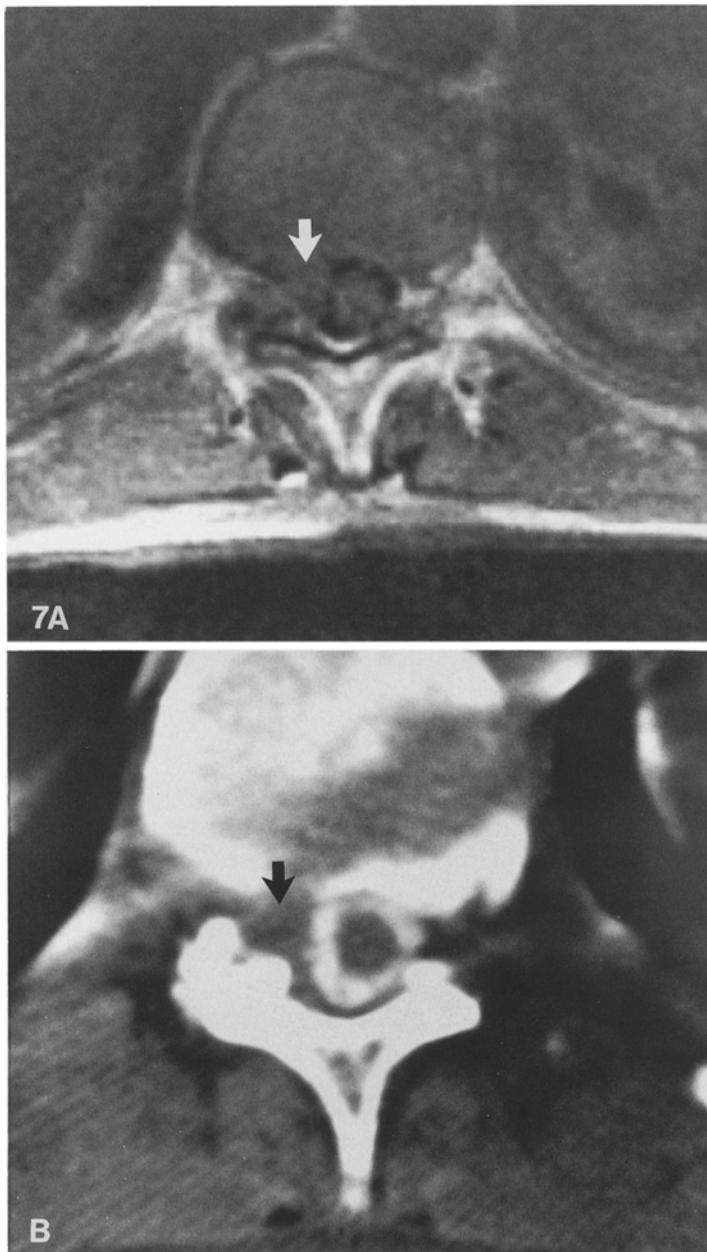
A This transaxial scan (SE, TR = 500/TE = 17) reveals a focal mass at the T11-12 level effacing the subarachnoid space on the right (*arrow*). B The postmyelographic CT scan confirms the MR findings (*arrow*). A herniated disc was found at surgery
